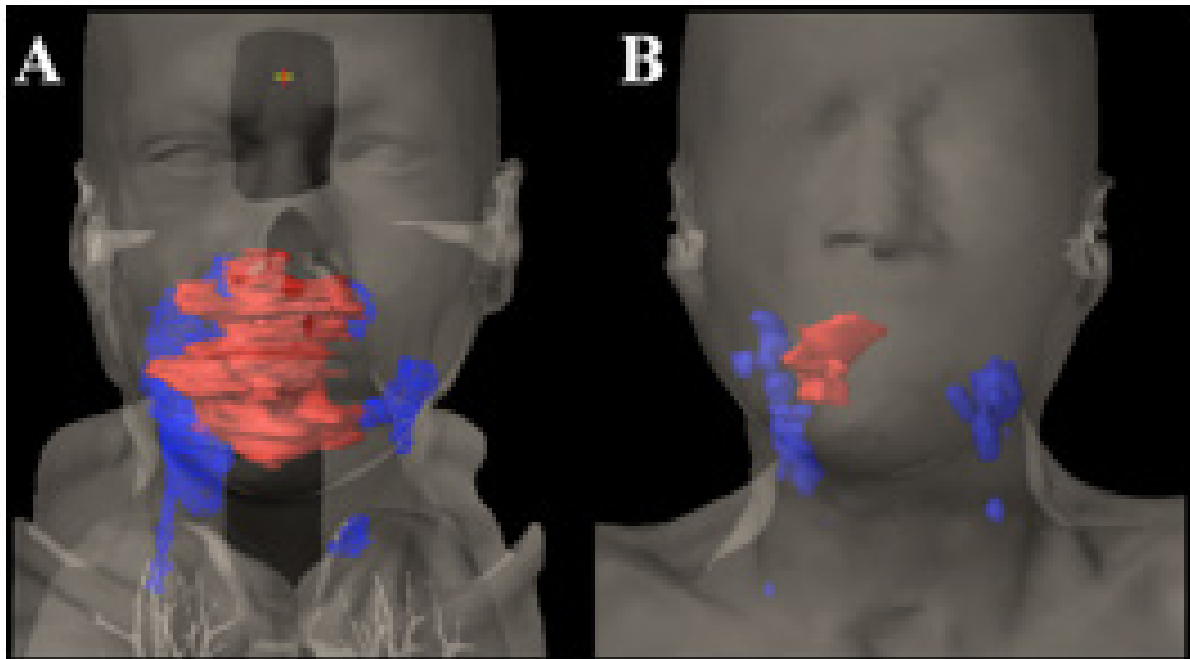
Primary tumor (red) and metastatic lymph node (blue) structures pre-(A) and post-IC (B) based on CT delineation.
